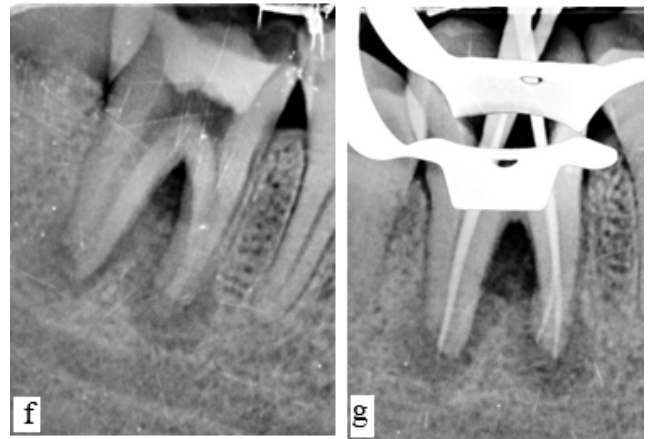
f: Intraoral radiograph of placement Calcium hydroxide intracanal medicament; g: Intraoral radiograph of showing mastercone selection
